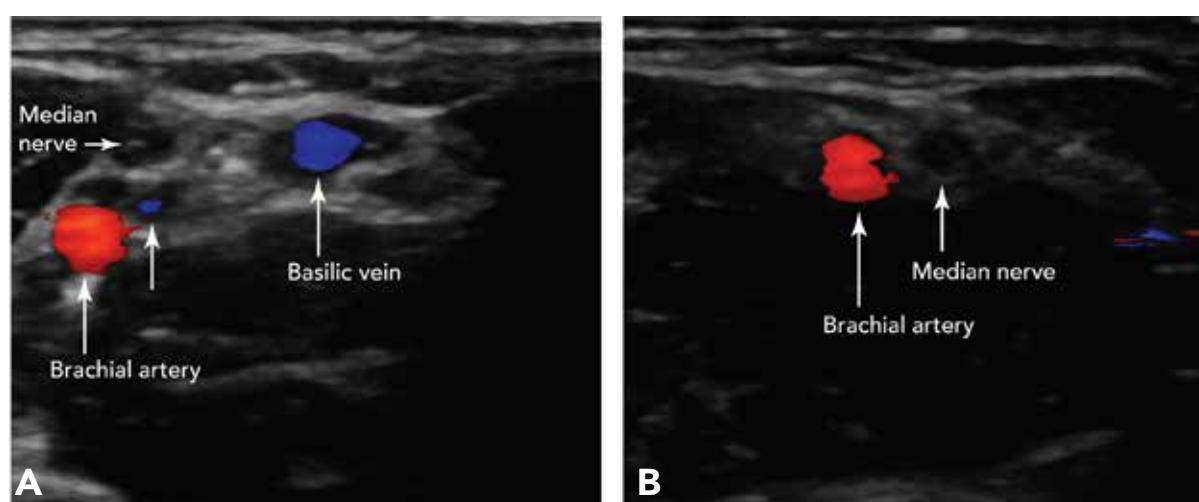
Brachial Artery Ultrasound with Color Doppler
